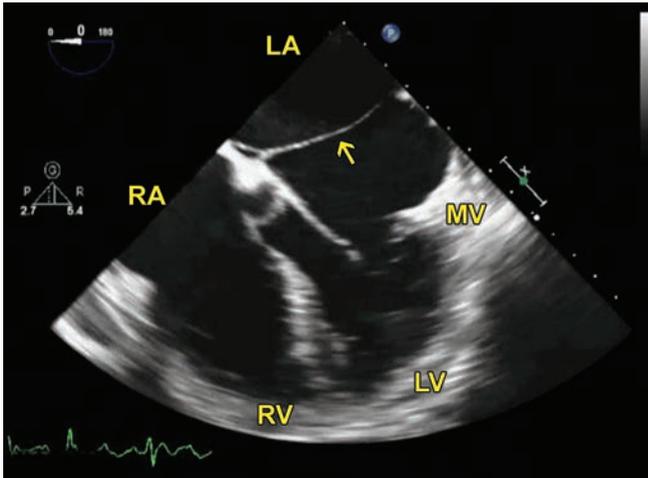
Transesophageal 4-chamber view. Arrow points to a linear echodensity in the left atrium.
